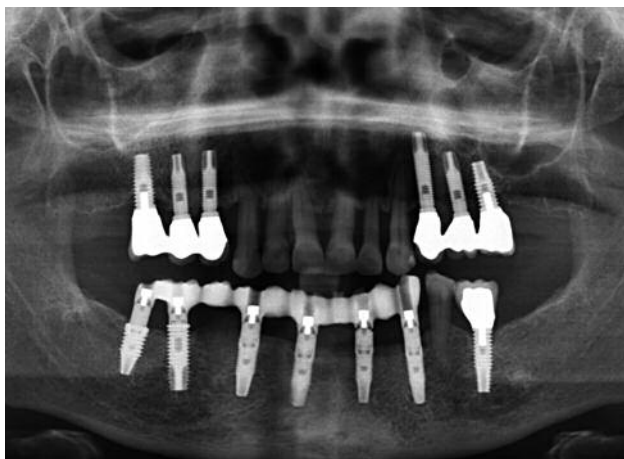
Radiographic image of the definitive prosthetic at one year. We can see the stability of all of the implants placed.
